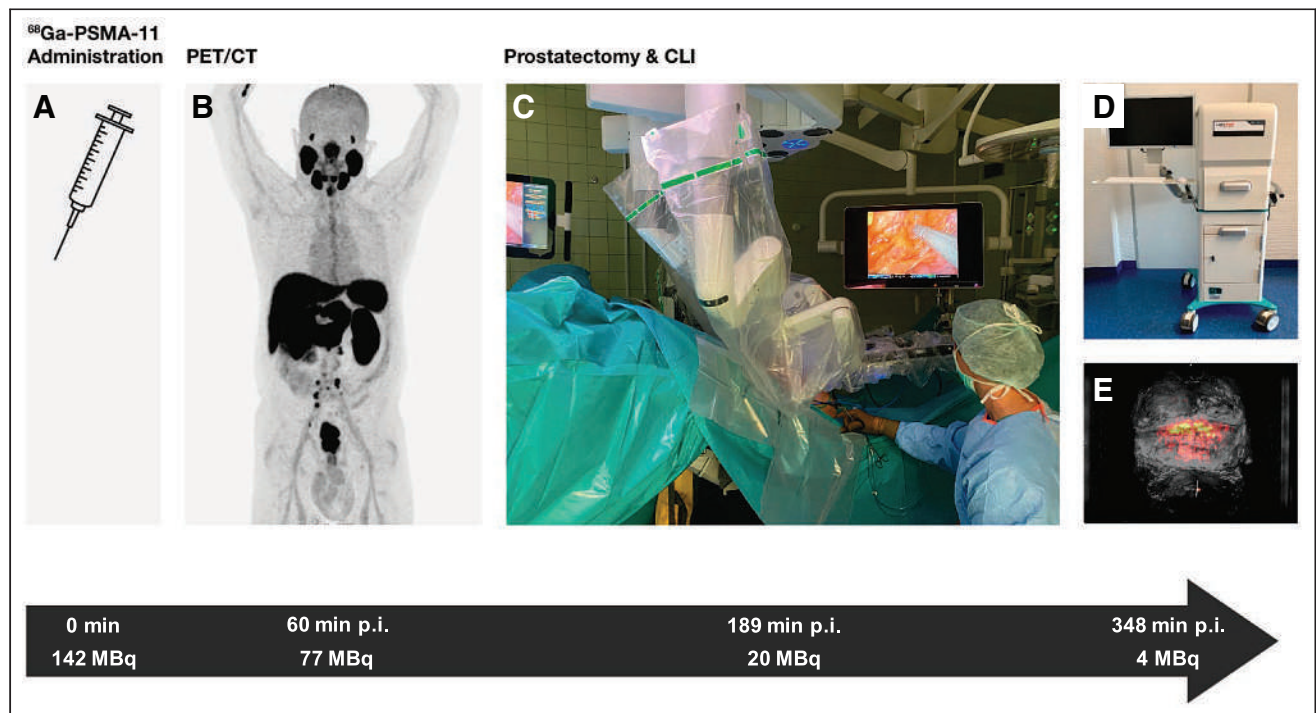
One-stop-shop protocol, including tracer administration (A), PET/CT imaging (B), and CLI during prostatectomy (C–E), permitted by remainder of ^{68}Ga -PSMA-11 uptake in prostate. Temporal sequence (black arrow) shows median time points after injection (p.i.) and decay-corrected whole-body activity expected for each step of protocol.
